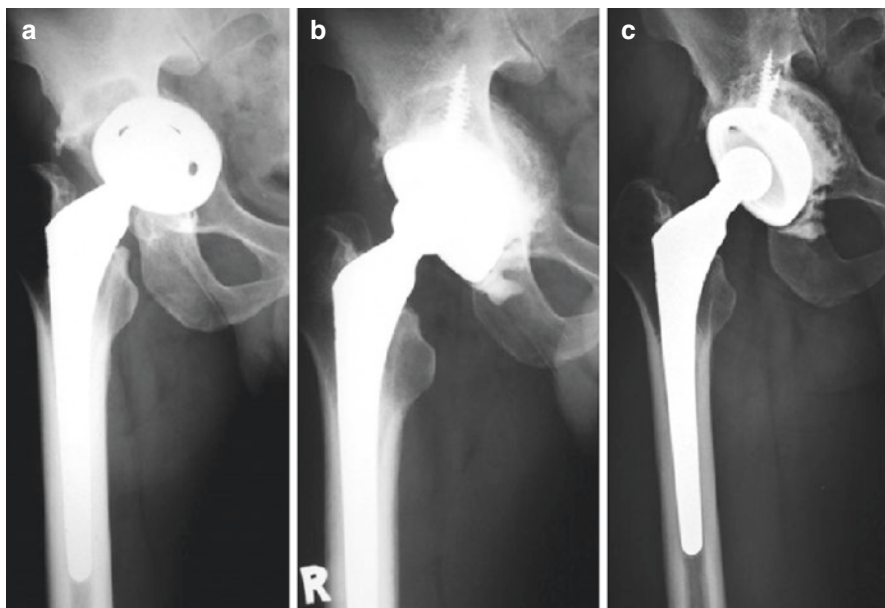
A 40-year-old man with aseptic loosening of the right THA. Type IIC defect with intrapelvic cup migration (a). Three months after revision of the acetabular component with morselized allograft to fill the medial defect and cemented fixation, the radiograph shows early consolidation of the allografts (b). Six years later, there was good incorporation of the graft without migration of the acetabular component (c) (these pictures were agreed by the patient for publication)
